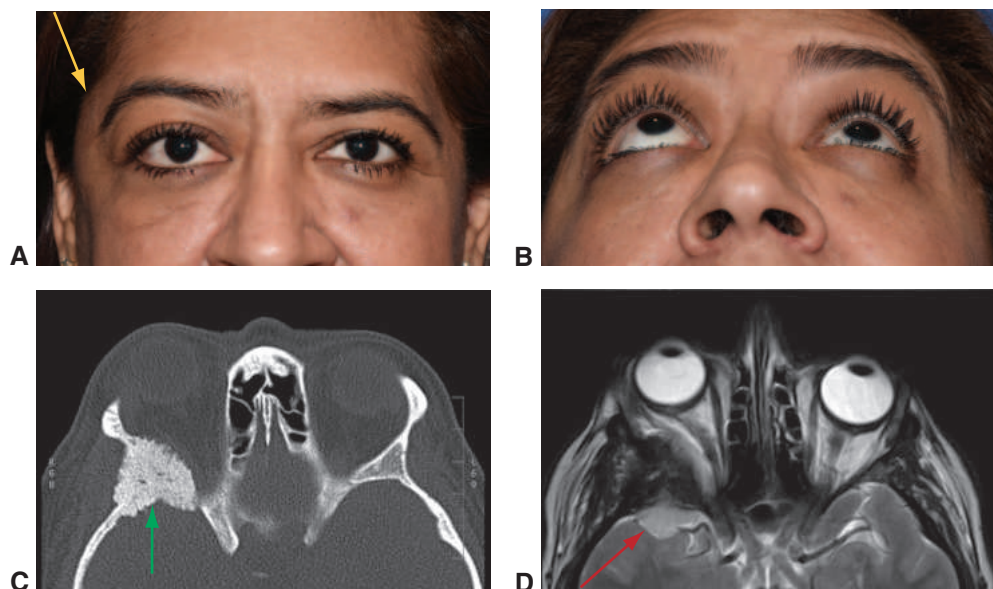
Sphenoid wing meningioma. A, Patient demonstrates right temporal fullness (arrow). B, Worm's eye view shows right proptosis. CT (C) and MRI (D) demonstrate hyperostosis of the sphenoid bone (green arrow) from the associated meningioma (red arrow). (Courtesy of Bobby S. Korn, MD, PhD.)
